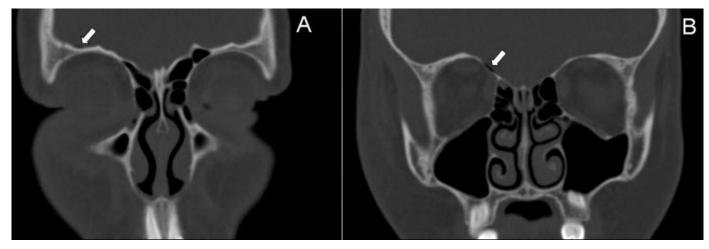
13-year-old male with comminuted right orbital roof "blow-in" fracture. Unenhanced CT orbits (obtained with a Siemens SOMATOM® Definition AS 128-slice CT scanner, Siemens Healthcare, using bone algorithm; axial acquisition of 0.6 mm thickness over the area scanned with subsequent reconstruction into 2 mm contiguous axial scans of 2 mm thickness reformatted in the coronal plane; bone window settings; 120 kV; 210 mAs; Total Dose: 354 mGy) demonstrates (a, b) 2 foci of intracranial air (arrows) in the anterior cranial fossa.
